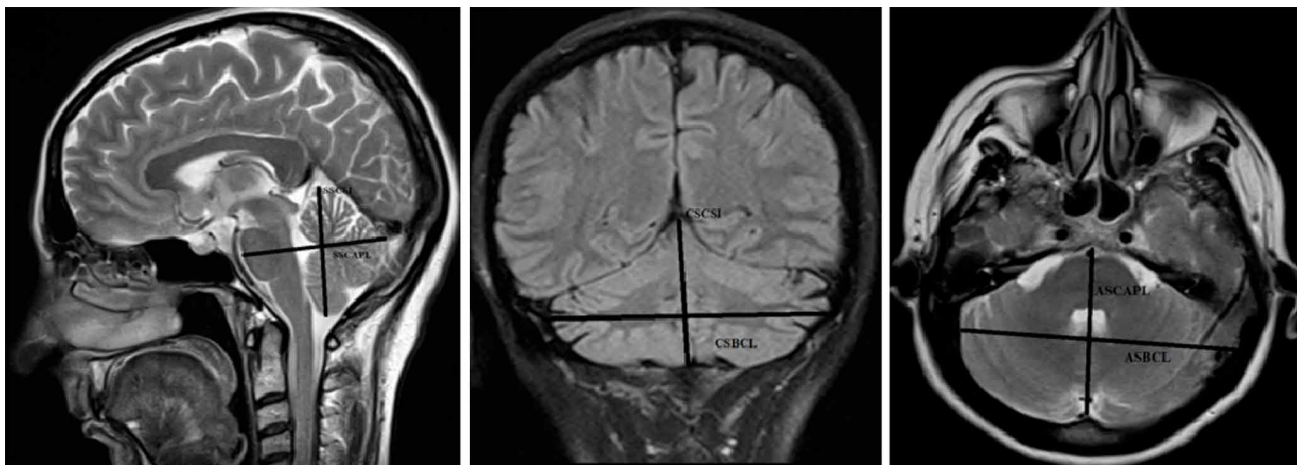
Demonstration of the maximum diameters of posterior fossa measurements on MRI and the cerebellum superior inferior and anterior posterior lengths on sagittal section, the bi-cerebellar length and cerebellum anterior posterior lengths on coronal and axial section.
